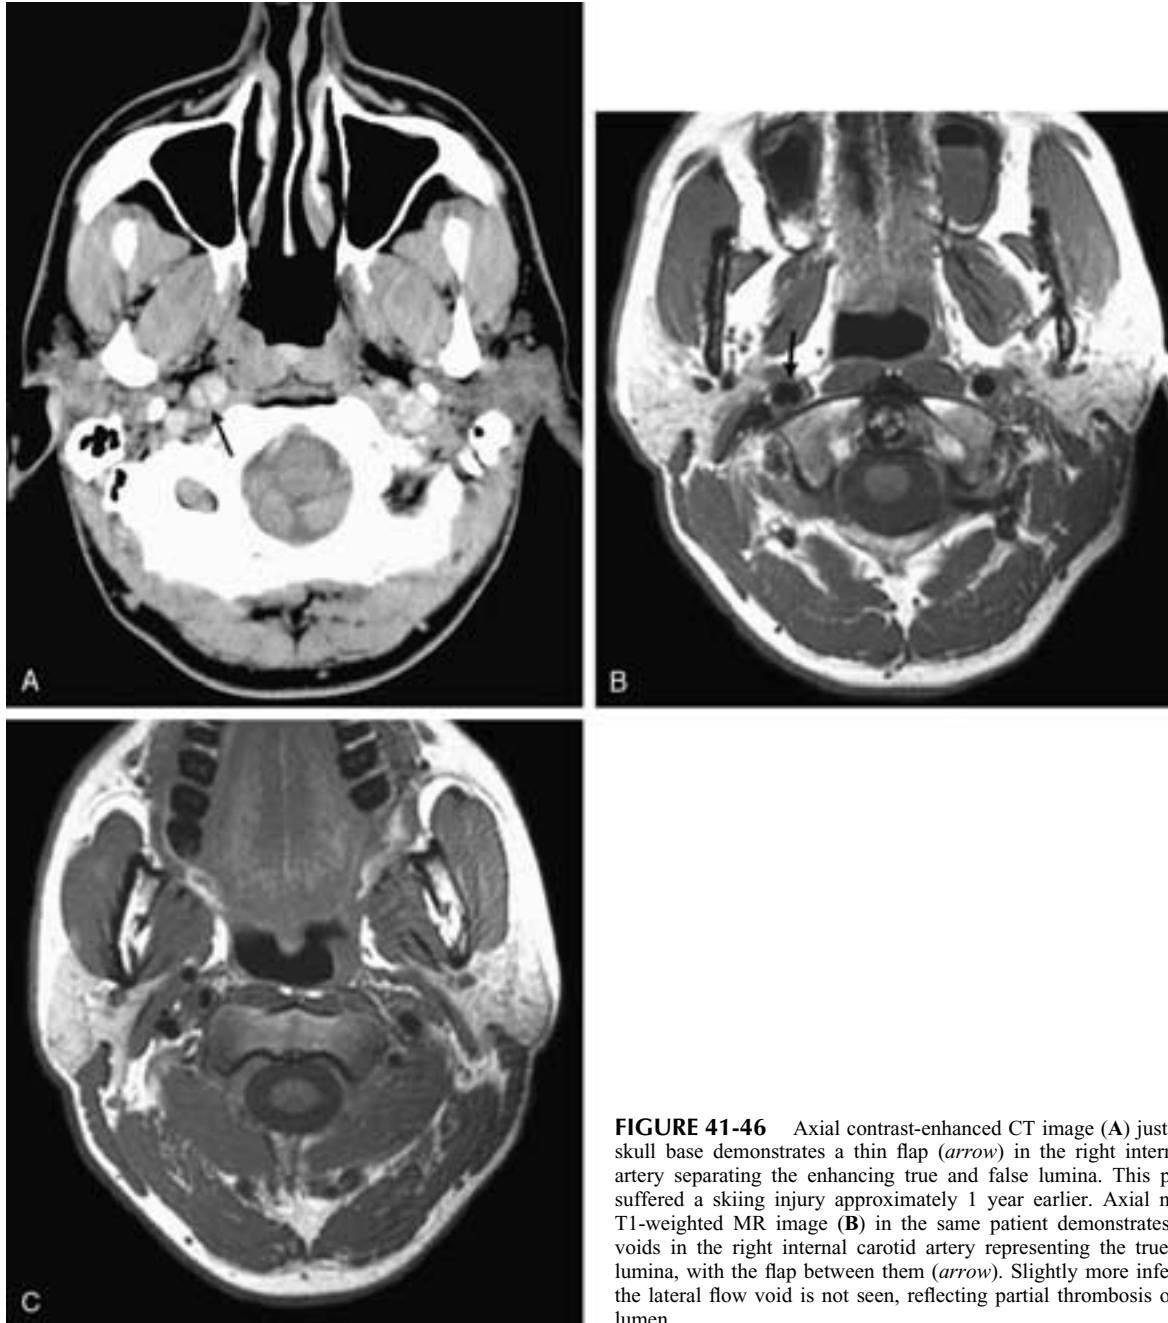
Axial contrast-enhanced CT image (A) just below the skull base demonstrates a thin flap (*arrow*) in the right internal carotid artery separating the enhancing true and false lumina. This patient had suffered a skiing injury approximately 1 year earlier. Axial noncontrast T1-weighted MR image (B) in the same patient demonstrates two flow voids in the right internal carotid artery representing the true and false lumina, with the flap between them (*arrow*). Slightly more inferiorly (C), the lateral flow void is not seen, reflecting partial thrombosis of the false lumen.
